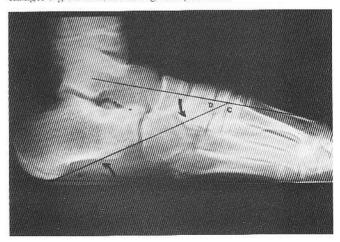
Supinated foot x-ray. A. Calcaneal inclination angle changes very little with supination. B. Talar declination angle changes quite a bit, decreasing with supination. D. The lateral talocalcaneal angle also changes a great deal, decreasing with supination.
